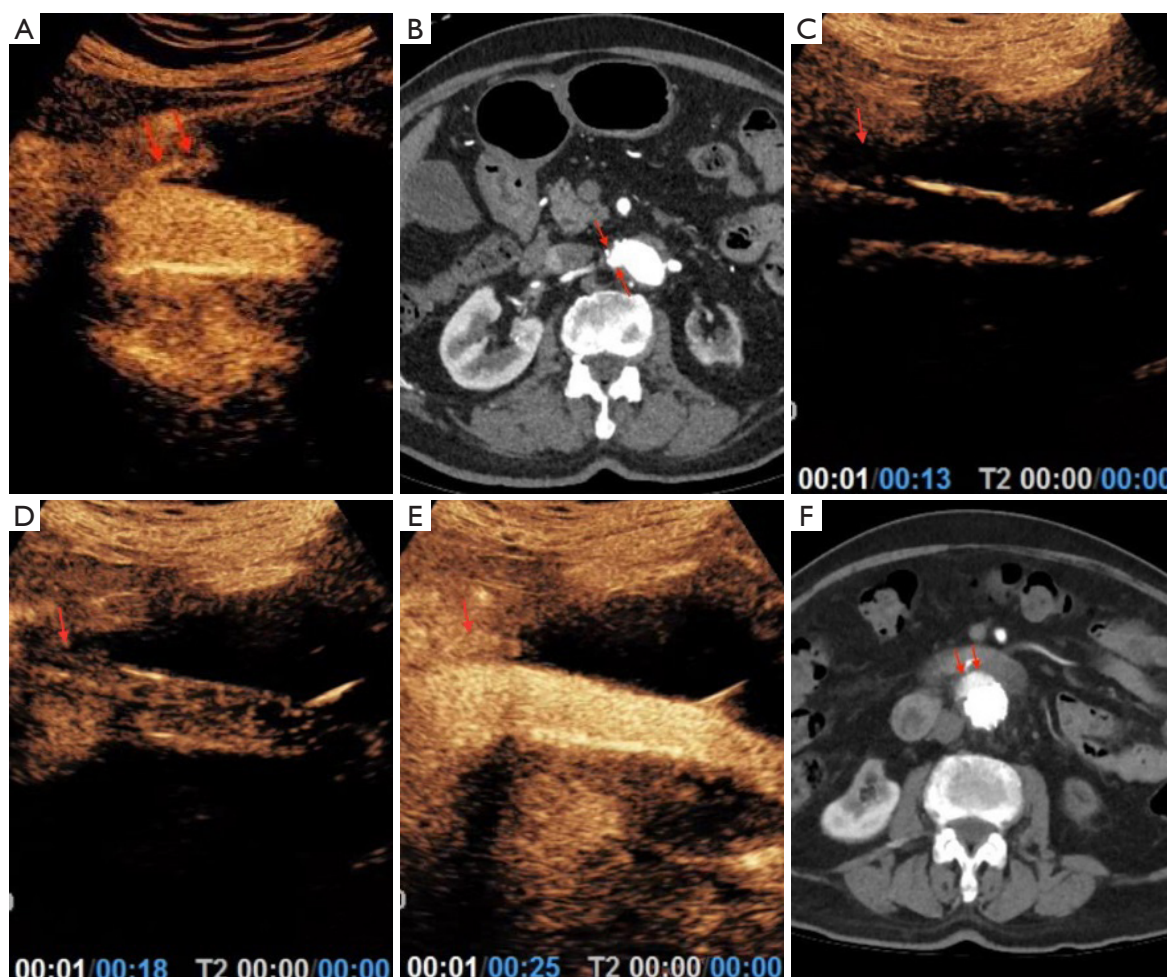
Scans of an 87-year-old male patient. Type Ia with type III endoleaks were found 70 months after EVAR surgery. (A) The position of the type Ia endoleaks near the proximal of the stent in CEUS (red arrows); (B) the position of the type Ia endoleaks near the proximal of the stent in CTA (red arrows); (C-E) the position of the type III endoleaks at the joint of the stent in CEUS (red arrows); (C) no contrast agent was observed in the stent or at the endoleak position when the contrast agent was injected for 13 s; (D) the simultaneous appearance of the arrow position and the contrast agent in the stent at 18 s; (E) the strength of the contrast agent in the endoleaks was the same as that in the stent at 25 s; (F) the position of the type III endoleaks at the stent connection in the CTA (red arrows). EVAR, endovascular aneurysm repair; CEUS, contrast-enhanced ultrasound; CTA, computed tomographic angiography.
